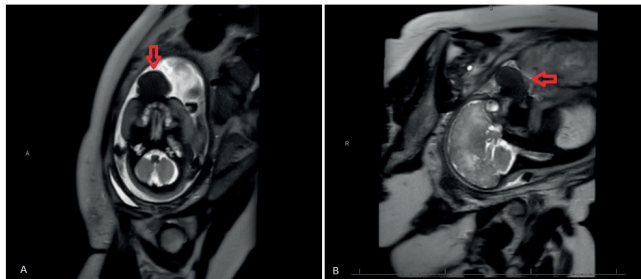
T2-weighted MRI showing a mass (red arrows) arising from right maxillary region (A) and extending through the mouth (B).
